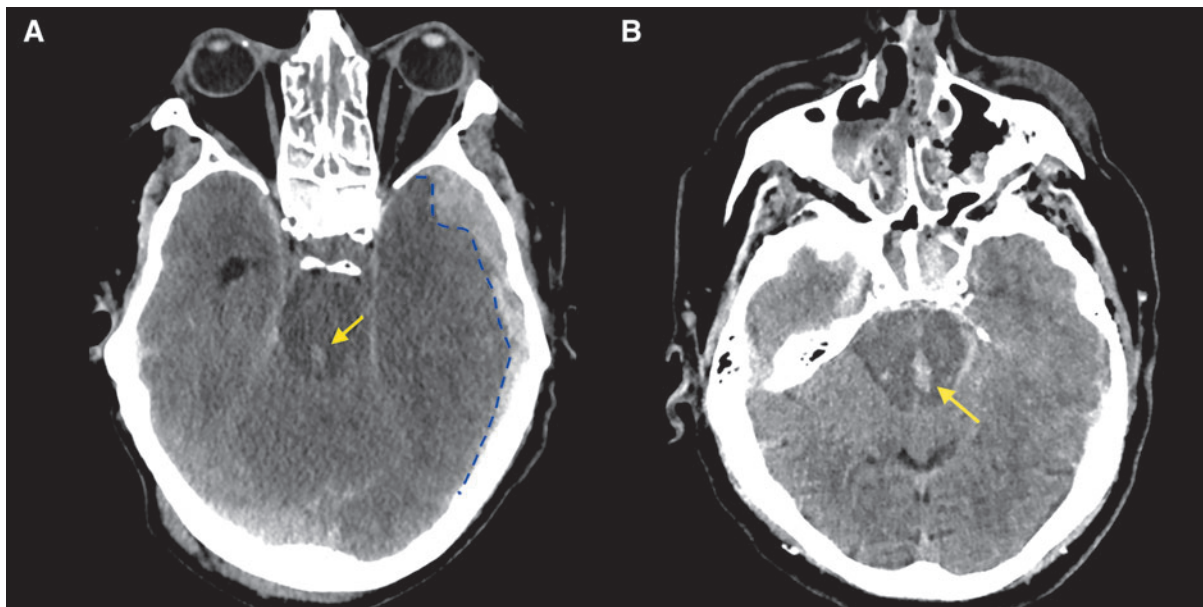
Axial non-contrast computed tomography images with soft tissue window of two different traumatic brain injury (TBI) patients with secondary brainstem hemorrhage. (A) Shows focal injury in the brainstem at the level of the pontomesencephalic junction (arrow). There is a left acute temporal subdural hematoma (SDH; blue dashed line), causing downward transtentorial herniation and obliteration of the basal cisterns. (B) Shows multiple hemorrhages in the pons and midbrain (arrow) in a patient with bilateral SDH, subfalcine and downward transtentorial herniation, midline shift (MLS), cisternal and ventricular compression (not shown).
